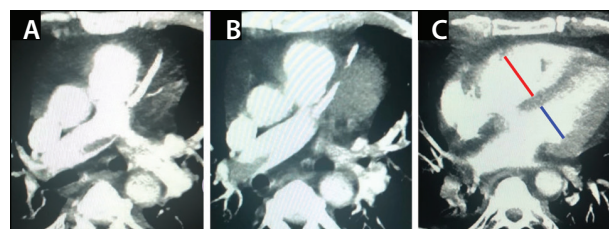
CT slices prior to thrombectomy. Thrombus at the main PA bifurcation, in the right PA, and in the segmental branches of the left PA (A, B). RV (red)/LV (blue) ratio was 1.2, indicating right heart strain (C).
